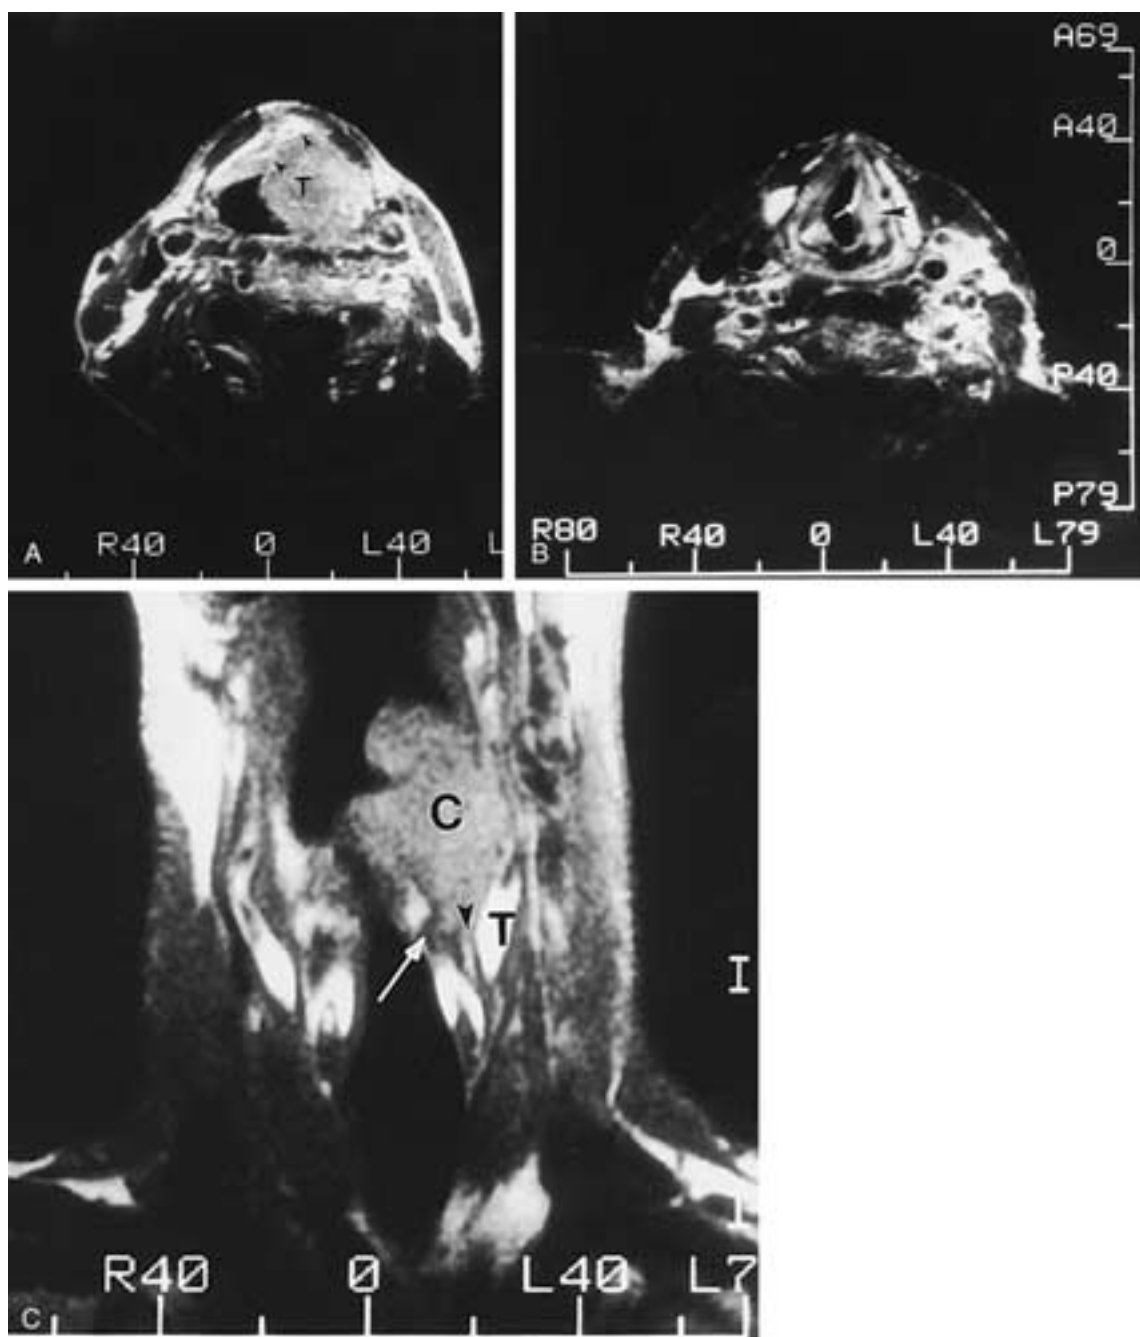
Supraglottic carcinoma crossing the ventricle via the paraglottic space. A, Axial T1-weighted image postcontrast. The tumor (*T*) is seen in the supraglottic larynx. Even with contrast, the margin (*arrowheads*) relative to the preepiglottic fat is clearly defined. B, Lower scan through the level of the cord. The tumor (*arrowhead*) is extending into the lateral portion of the TAM (*arrow*). This indicates that the lesion has crossed the ventricle into the true cord. C, Coronal image shows the carcinoma (*C*) following the paraglottic space around the ventricle. A very small amount of tumor (*arrowhead*) is squeezing between the thyroid cartilage (*T*) and the TAM (*arrow*). The upper edge of the muscle would indicate the level of the ventricle.
